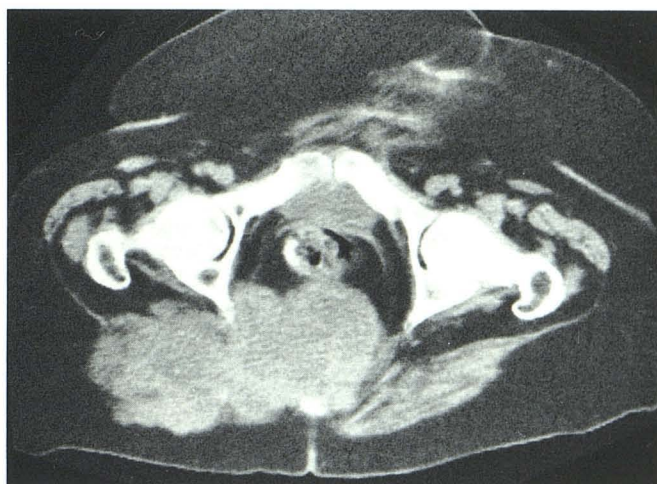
Case 9: right buttock and lower extremity pain. CT demonstrates large pelvic mass destroying sacrum and extending through GSF into right
